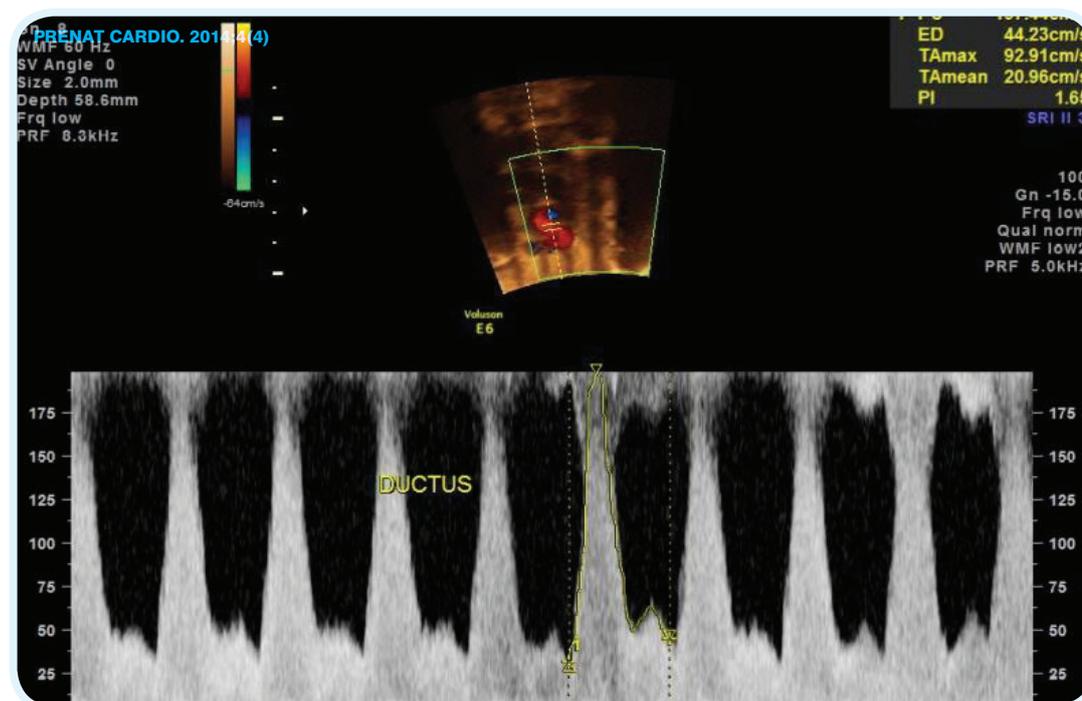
Pulsed Doppler tracing of a ductal flow in a 31 weeks fetus with constriction of DA caused by maternal ingestion of dark chocolate and grape juice. There is high systolic and diastolic peak velocities, as well as a decrease pulsatility index.
